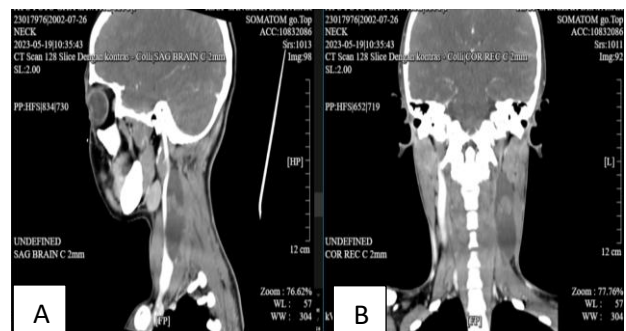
(A and B): CT scan of the patient.
